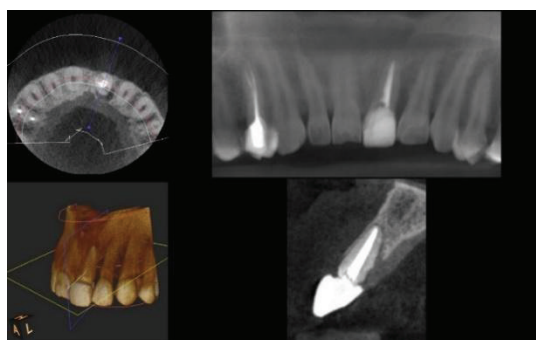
CBCT showing badly destroyed maxillary left central incisor.
